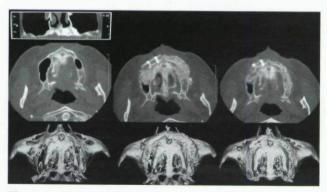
Computed tomographic scans of a study patient's maxilla preoperatively, postoperatively, and after 6 months of healing after the bone graft.
